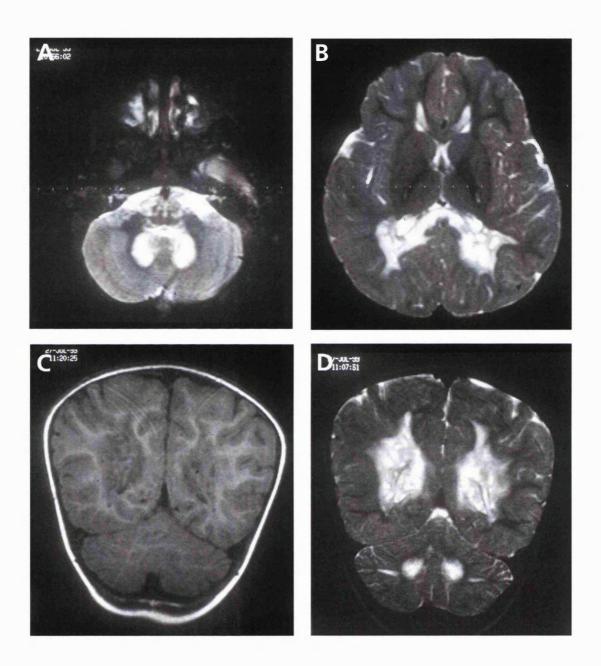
MRI brain of P37
